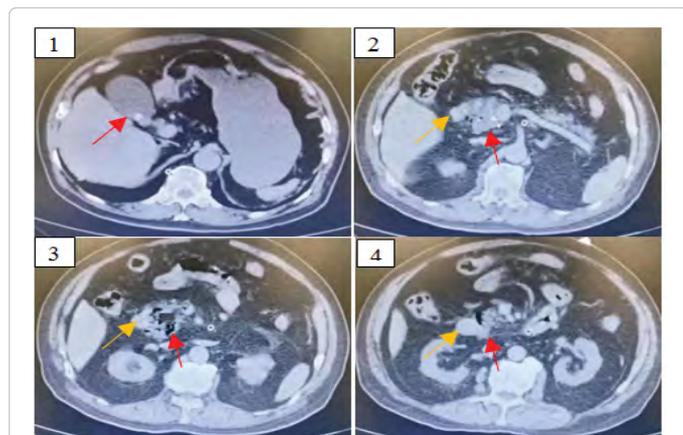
(1-4): Imaging findings of abdominal CT scan. Large diverticulum in the descending part of duodenum with the dilatation of common bile duct and pancreatic duct as shown on CT.
